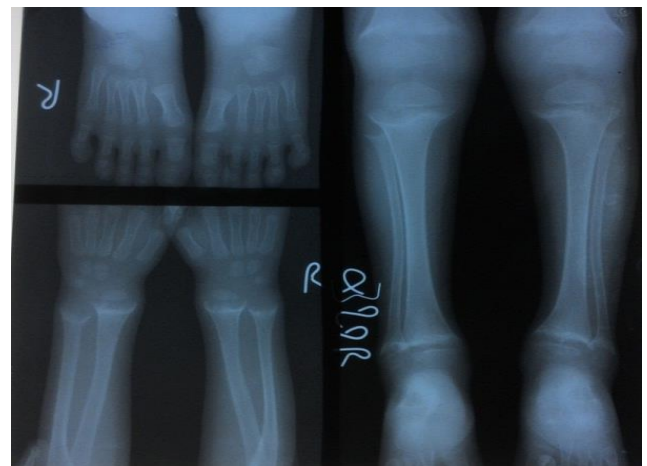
X-ray both hands with wrist.
